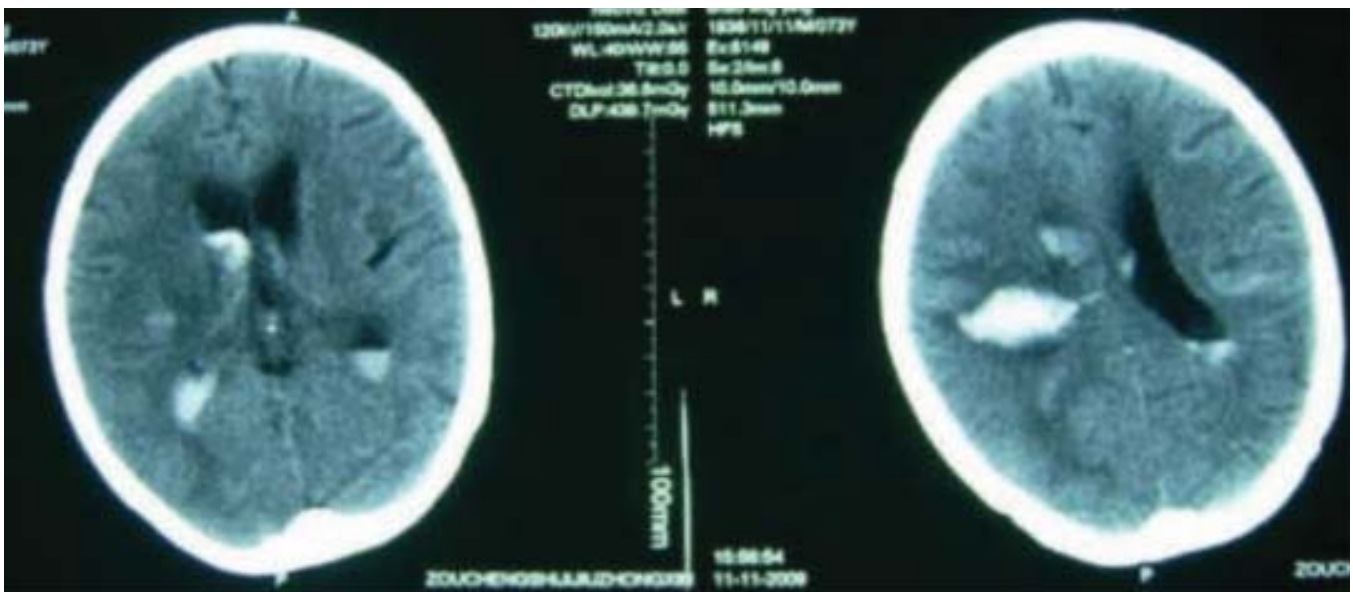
CT image of a patient with a brain.
